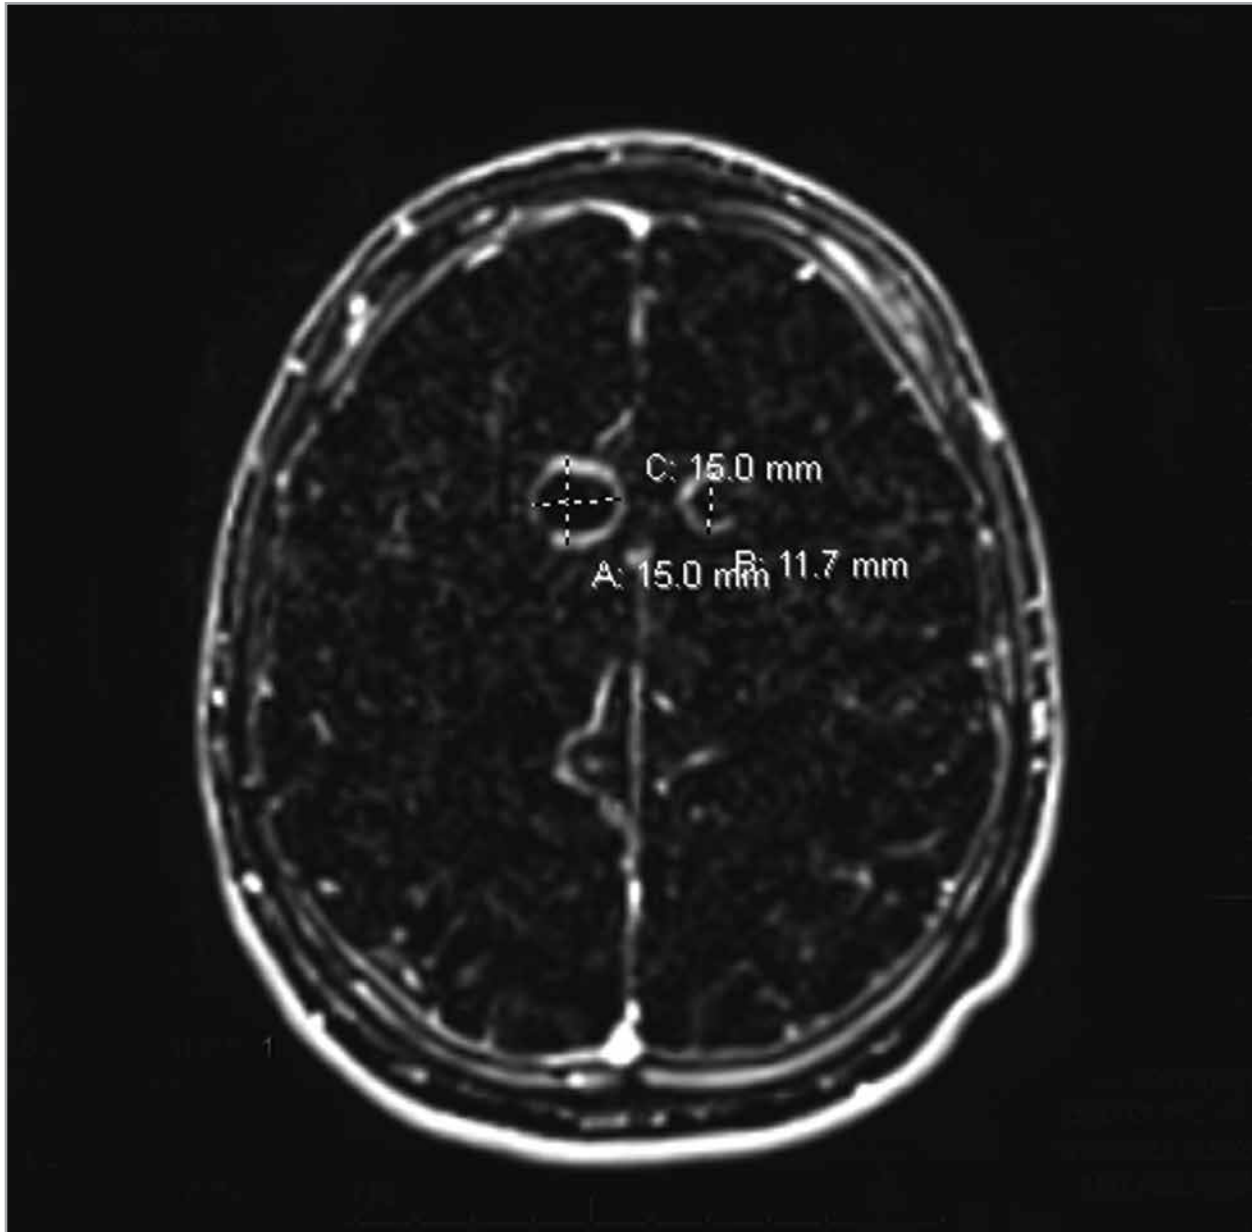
Posttreatment subtraction magnetic resonance image of the brain shows coverage ablation cavities within the bilateral anterior cingulate gyri with thin peripheral reactive enhancement and restricted diffusion. The right cavity approximates 1.5 cm (A) x 1.2 cm (B), and the left cavity measures 1.5 cm (C).
